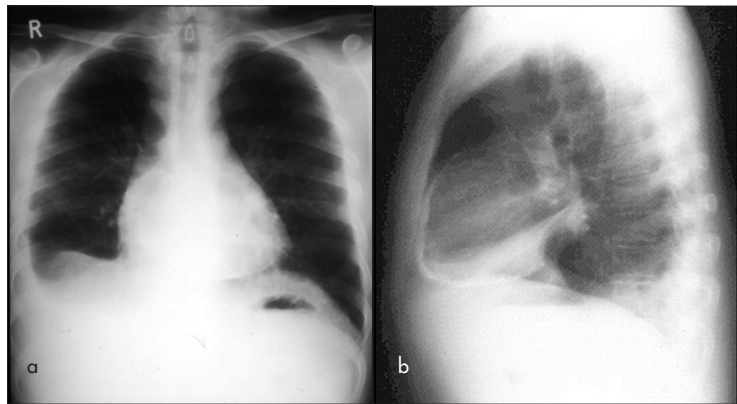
Pericardial calcification on chest X-ray.
